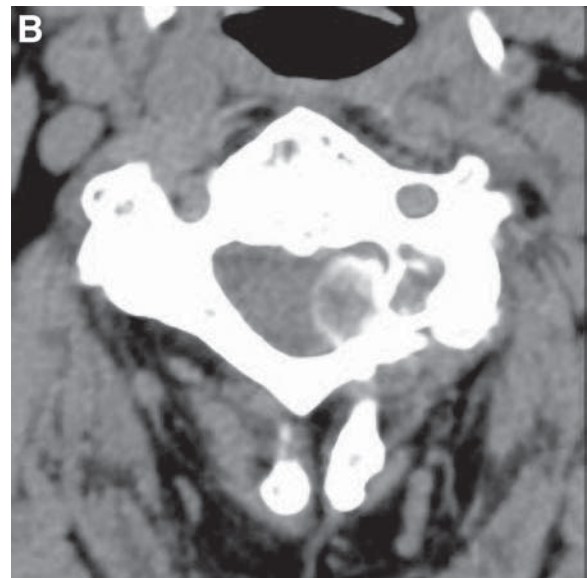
(A) Axial CT filmed on bone windows demonstrates prominent left-sided facet joint degeneration at C2–3. (B) Soft tissue windows is just caudal to image (A) at the C3 level. It reveals an extradural mass with mural calcification that causes moderate spinal canal stenosis. The findings are typical for a synovial cyst. This case was confirmed surgically.
